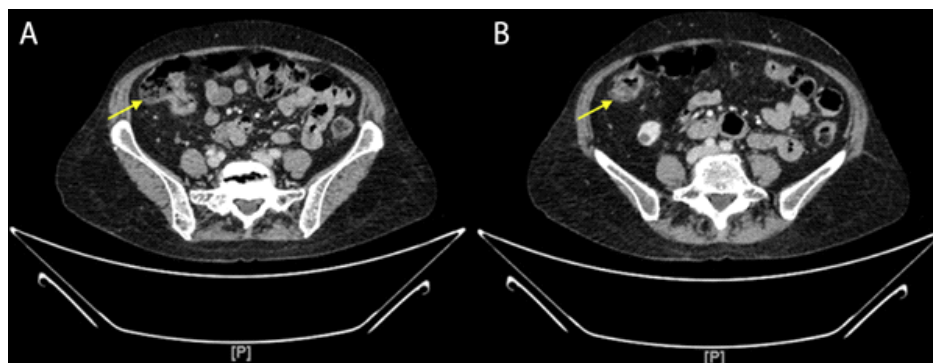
Abdominal CT scan Ileocecal wall thickening is shown in panel A (yellow arrow); Mass projecting in the ascending colon is shown in panel B (yellow arrow)
